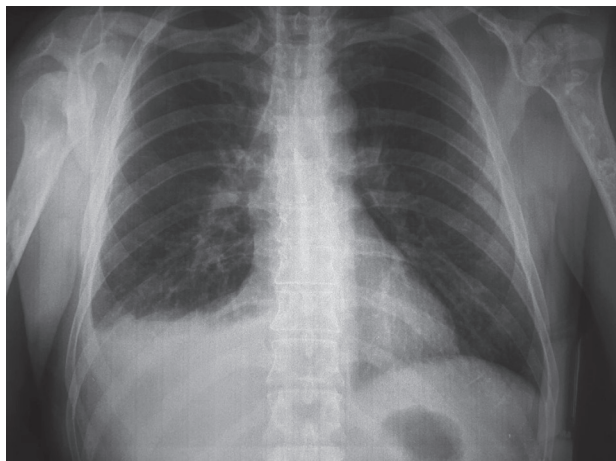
Chest X-ray at follow – up one month later reveals complete remission of the pleural effusion at the left side and a small amount of pleural effusion at the right side.
